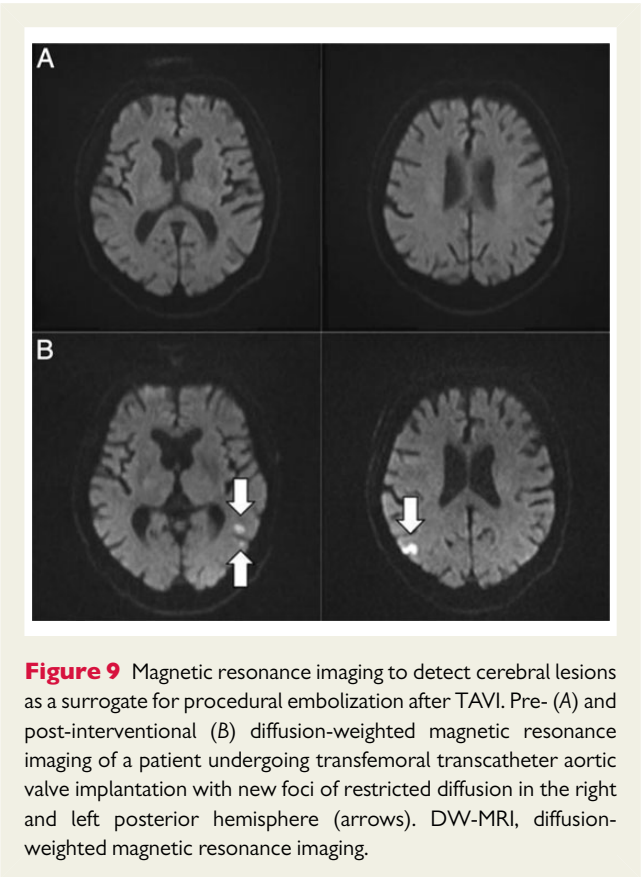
Magnetic resonance imaging to detect cerebral lesions as a surrogate for procedural embolization after TAVI. Pre- (A) and post-interventional (B) diffusion-weighted magnetic resonance imaging of a patient undergoing transfemoral transcatheter aortic valve implantation with new foci of restricted diffusion in the right and left posterior hemisphere (arrows). DW-MRI, diffusion-weighted magnetic resonance imaging.
